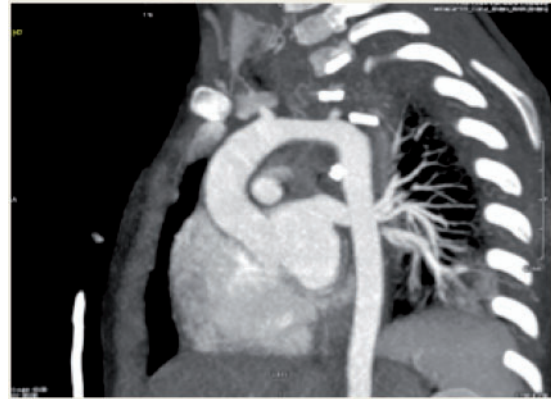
Computed tomography scan 15 days after surgery: the calibre of the aorta is regular without residual coarctation or aneurysm.
